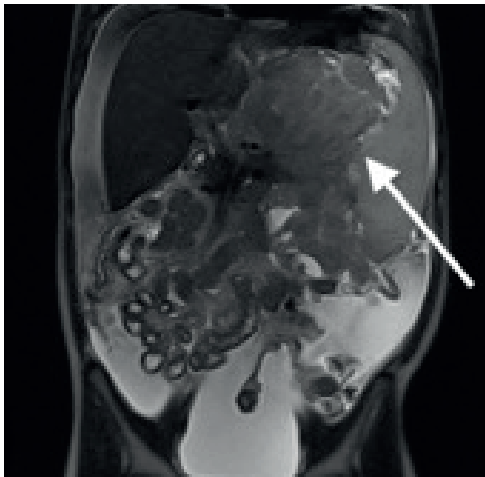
CT image of the abdominal mass located in the posterior region of the stomach at presentation (Patient 1)
